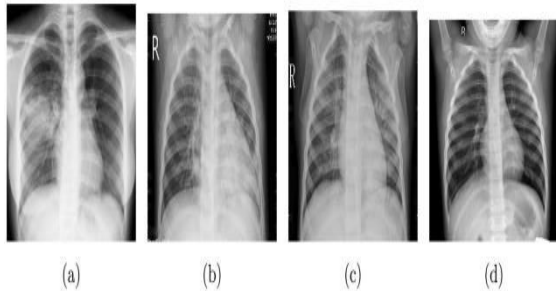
X-ray images a COVID-19, b viral pneumonia, c bacterial pneumonia, d normal from COVID19-XRay-data
